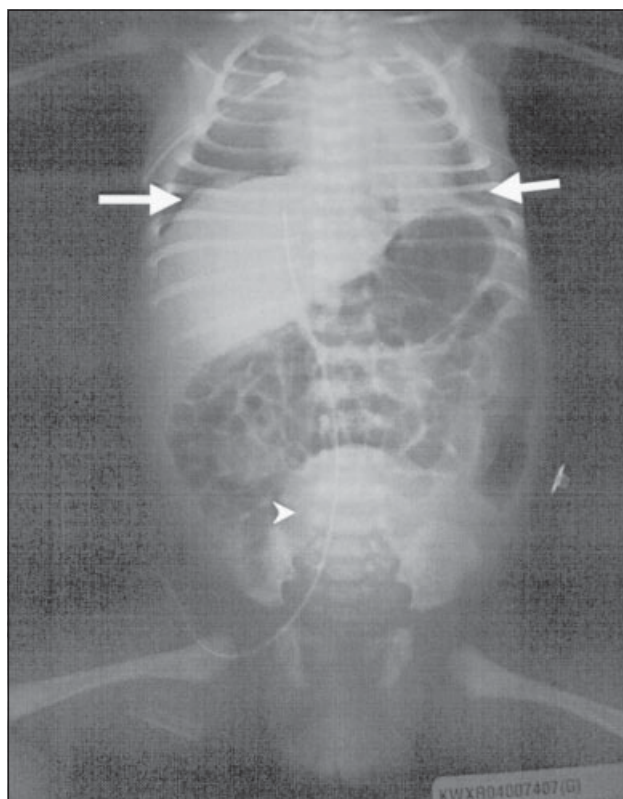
ray showing bilateral lung hypoplasia and pneumothorax (arrows), chest tubes in situ, and a grossly distended urinary bladder (arrow head)
